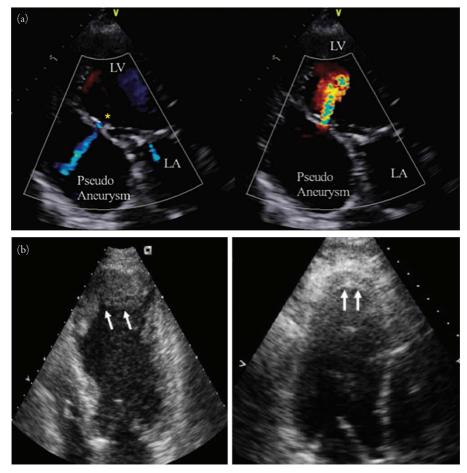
(a) Ventricular pseudoaneurysm. Note that the neck (*) of a left ventricular (LV) pseudoaneurysm is narrow compared to that of a LV aneurysm. From Figure 1C and 1E of Shimono H, Kajiya T, Atsuchi Y, Atsuchi N, Ohishi M. Giant left ventricular pseudo-aneurysm after posterior myocardial infarction. Euro Heart J. 2018;39(37):3479. (b) Apical thrombi. The image on the left shows a large and readily visualized left ventricular thrombus, while the image on the right shows a more subtle thrombus that may require echo contrast, transesophageal echocardiography, or cardiac magnetic resonance imaging to confirm. Adapted from Figure 2 of Srichai MB, Junor C, Rodriguez LL, et al. Clinical, imaging, and pathological characteristics of left ventricular thrombus: a comparison of contrast-enhanced magnetic resonance imaging, transthoracic echocardiography, and transesophageal echocardiography with surgical or pathological validation. Am Heart J. 2006;152(1):75–84.
